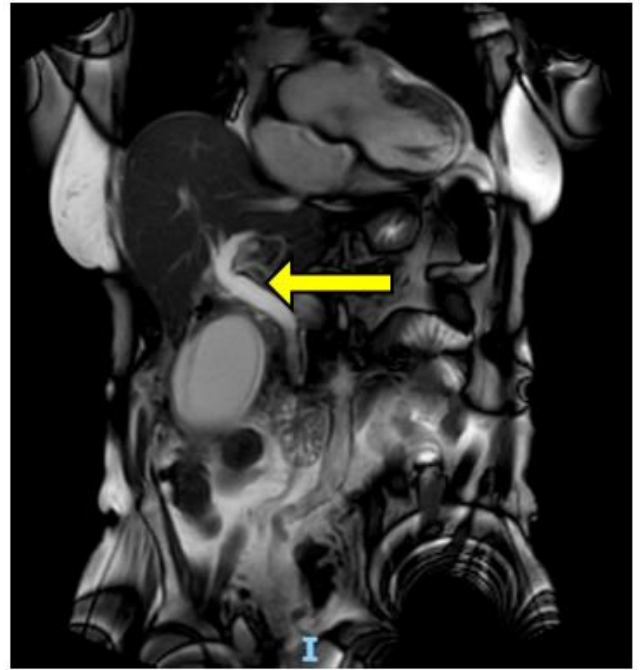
Ultrasound scan and MRCP supporting the findings a distended gallbladder and dilated common bile duct
